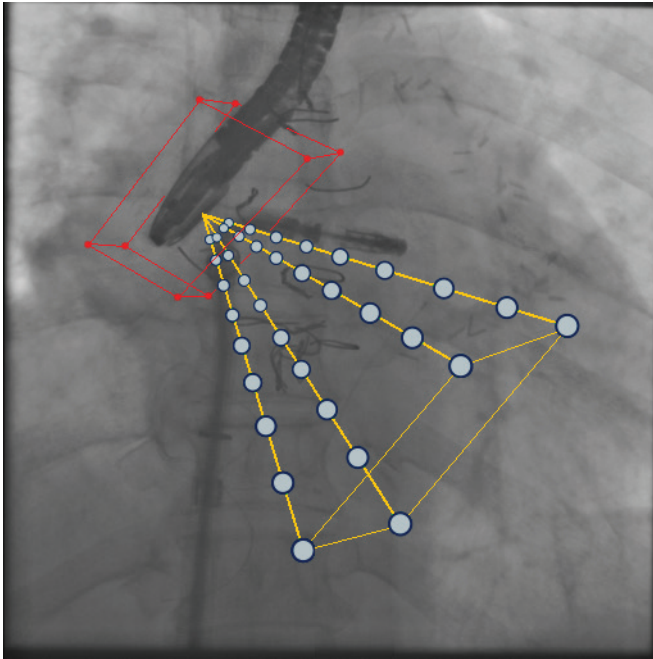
Possible visualization of a registration of a TEE probe. The 2D/3D registration inherently provides a registration of the ultrasound (symbolized as pyramid structure) to the X-ray image
